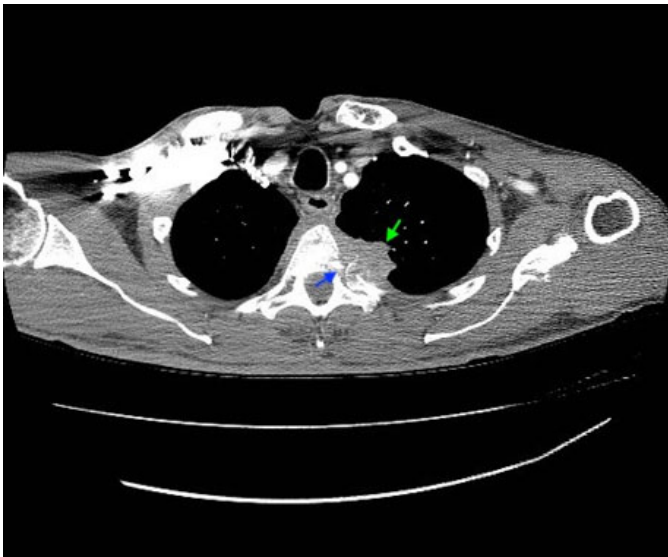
Axial computed tomography scan with IV contrast. The pleural mass measuring 3.2 cm (green arrow) can be seen invading the left fourth costochondral junction and vertebral body (blue arrow).
